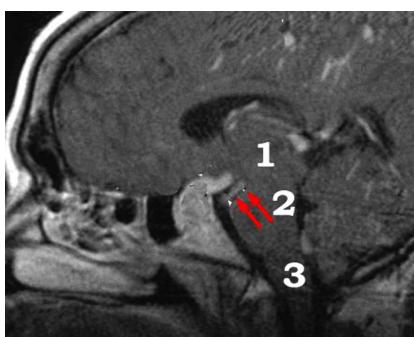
Contrast-enhanced T1-weighted parasagittal image shows enhancing lesion causing thickening and enhancement of cisternal segment of third cranial nerve (arrows); 1 – The midbrain; 2 – The pons; 3 – The bulbus.
